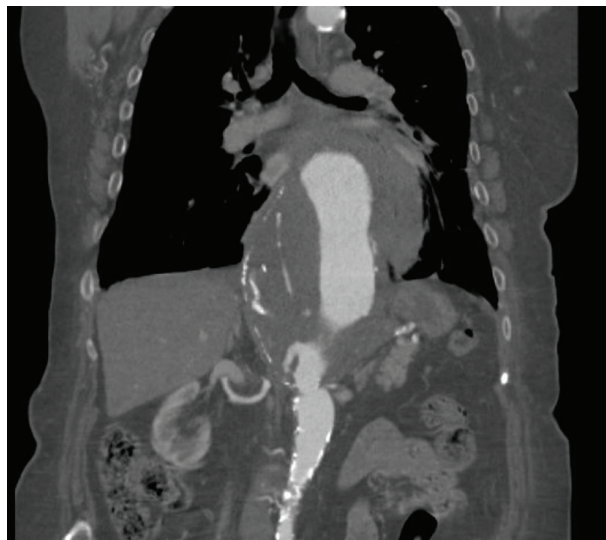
Coronal CT view of the aneurysm.
